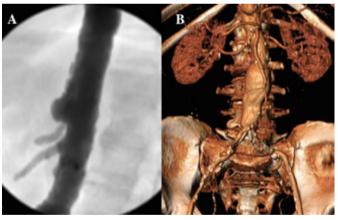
Pre-operative CTA revealed a para-visceral saccular aneurysm just above the orifice of the celiac axis (Panel A) and an infrarenal AAA (Panel B).
